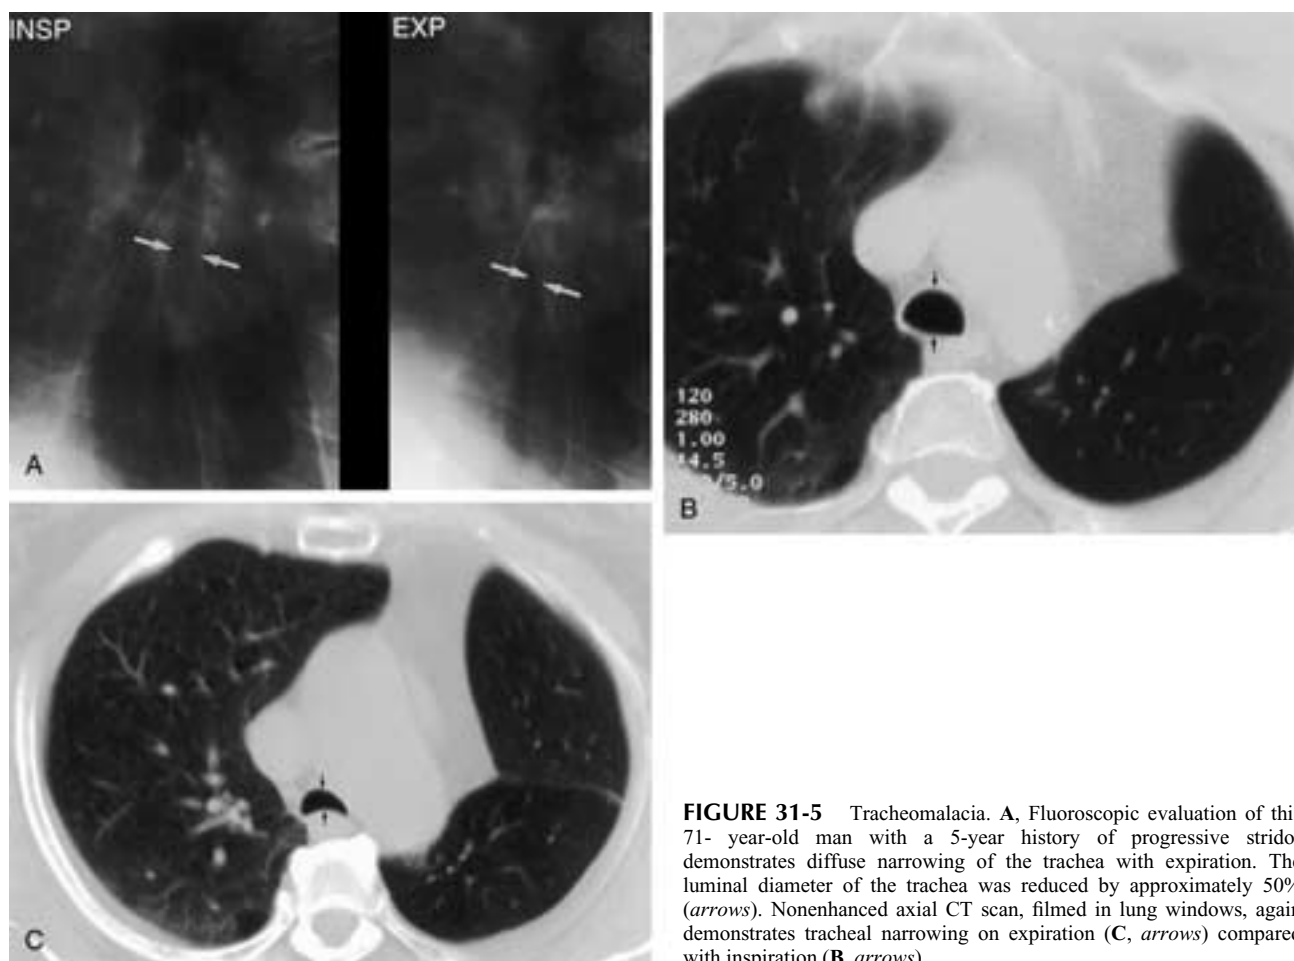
Tracheomalacia. A, Fluoroscopic evaluation of this 71-year-old man with a 5-year history of progressive stridor demonstrates diffuse narrowing of the trachea with expiration. The luminal diameter of the trachea was reduced by approximately 50% (arrows). Nonenhanced axial CT scan, filmed in lung windows, again demonstrates tracheal narrowing on expiration (C, arrows) compared with inspiration (B, arrows).
